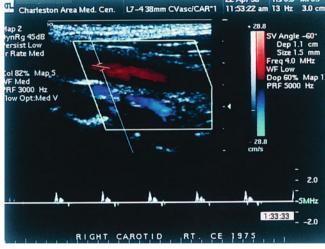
A color duplex ultrasound image of a patient with occlusion of the internal carotid artery, which is usually associated with a loss of the diastolic component in the ipsilateral common carotid artery (*bottom*)
